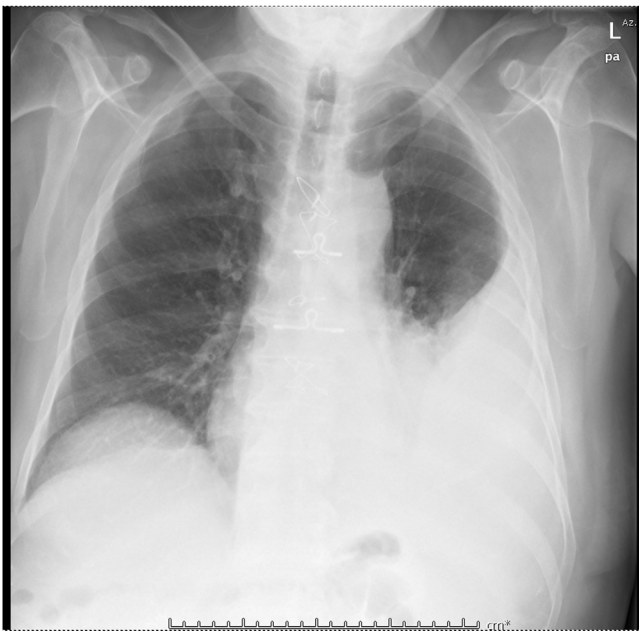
Chest radiograph after pleural effusion relapse with no evidence of chylothorax at physical and chemical examination.
